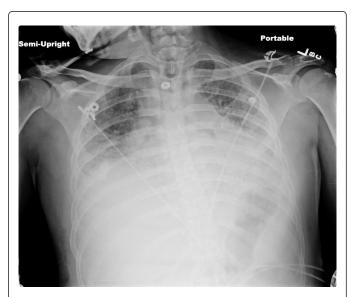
Patient Chest X-ray on admission.
